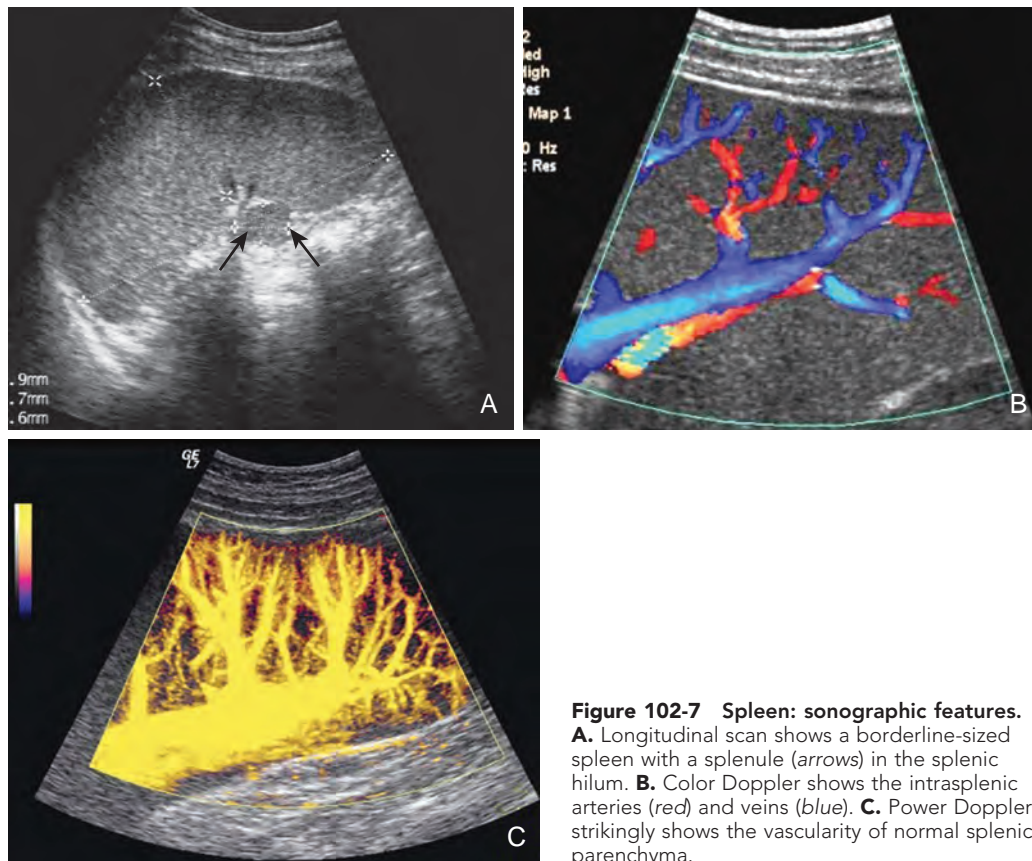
Spleen: sonographic features.
